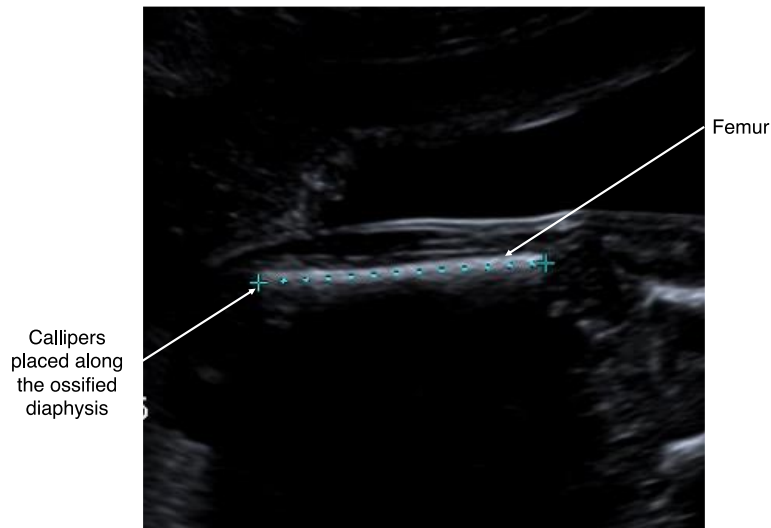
Ultrasound view required for the measurement of femur length (FL) >14 weeks gestation.
